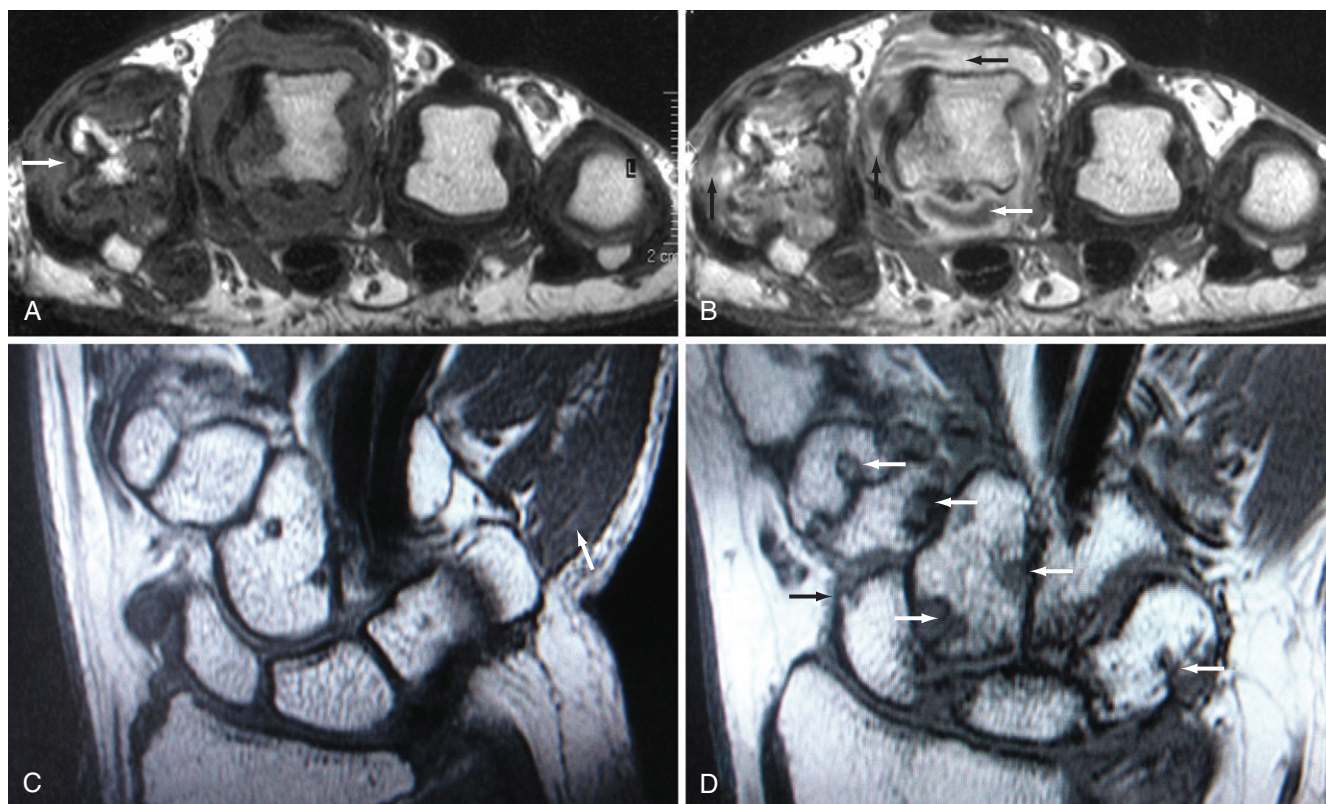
Rheumatoid arthritis (magnetic resonance imaging [MRI]). Axial T1-weighted precontrast (A) and postcontrast (B) MRI of the second (left) through fifth (right) fingers at the level of the metacarpophalangeal joints in a patient with rheumatoid arthritis (RA). Synovitis (black arrows in B), joint effusion (white arrow in B), and severe bone erosion (arrow in A) are seen. Coronal T1-weighted precontrast MRI of the wrist (C) in another RA patient shows no bone erosions. Similar images 1 year later (D) show severe erosive progression (bone erosions marked by arrows).
